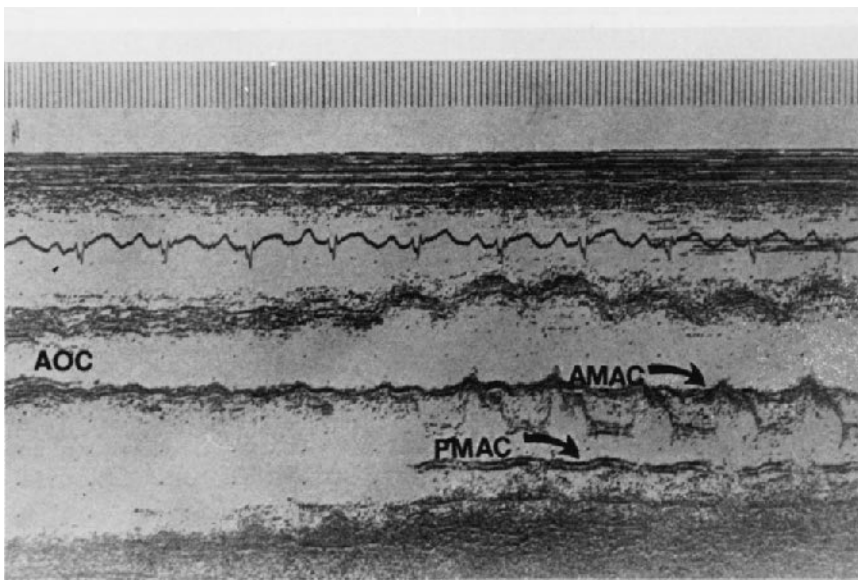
M-mode echocardiogram with scan from the aortic root to the left ventricular apex in a patient with both anterior and posterior mitral annular calcium. AOC = aortic calcium; AMAC = anterior mitral annular calcium; PMAC = posterior mitral annular calcium.
